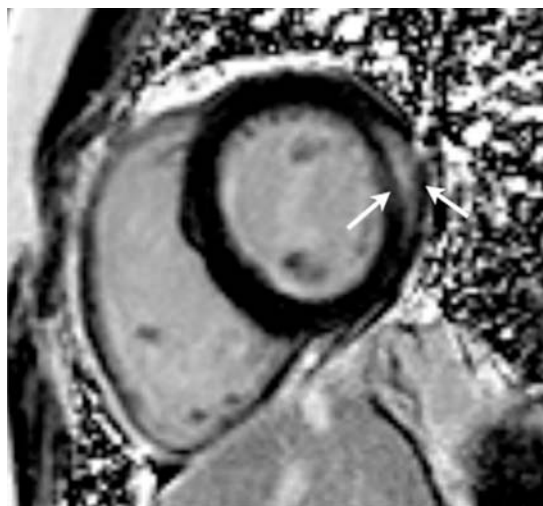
Cardiac magnetic Resonance Imaging Demonstrates a Short Axis View of the Left and Right Ventricles, With a Short Axis Phase-Sensitive Reconstructed Inversion Recovery-True Fast Imaging With Steady-State Precession Image Through the Midventricle at the Level of the Papillary Muscle, Demonstrating mid-myocardial Delayed Enhancement (arrows) in the Lateral Wall of a Patient Who Developed Trastuzumab-Induced Cardiotoxicity. (Reproduced from Fallah-Rad N1, Walker JR, Wassef A, et al. The utility of cardiac biomarkers, tissue velocity and strain imaging, and cardiac magnetic resonance imaging in predicting early left ventricular dysfunction in patients with human epidermal growth factor receptor II-positive breast cancer treated with adjuvant trastuzumab therapy. *J Am Coll Cardiol.* 2011;57:2263–2270 with permission.)
